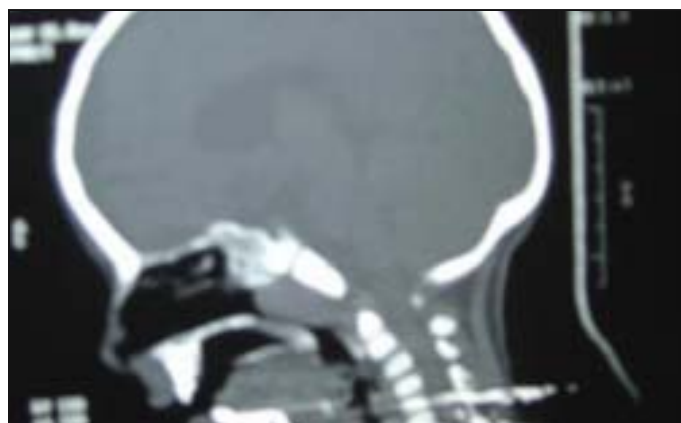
Spiral CT scan showing adenoid hypertrophy obstructing the airway
